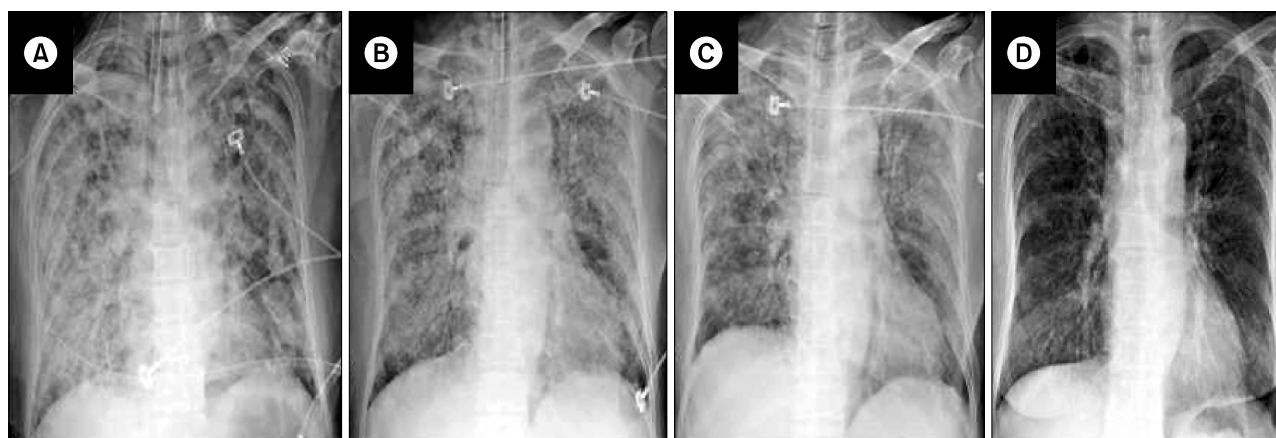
Chest X-rays at intensive care unit showed gradual improvement. On hospital day 3 mechanical ventilator care and steroid pulse therapy were started (A). On hospital day 5, both lung consolidations were improved (B). On hospital day 9, extubation was done (C). On hospital day 13, the patient was discharged from the hospital (D).
